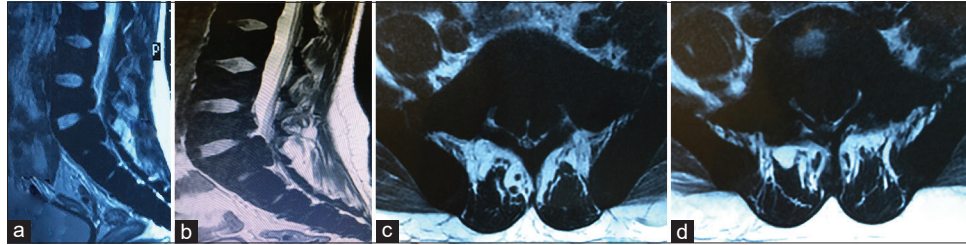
(a and b) Sagittal T2-weighted images showing L5, S1 level anterior epidural hypointense lobulated mass lesion attached to the posterior surface of the vertebral body with severe canal stenosis. (c and d) Axial T2-weighted images showing bi-lobulated lesion protruding from the vertebral body with near total canal stenosis.
